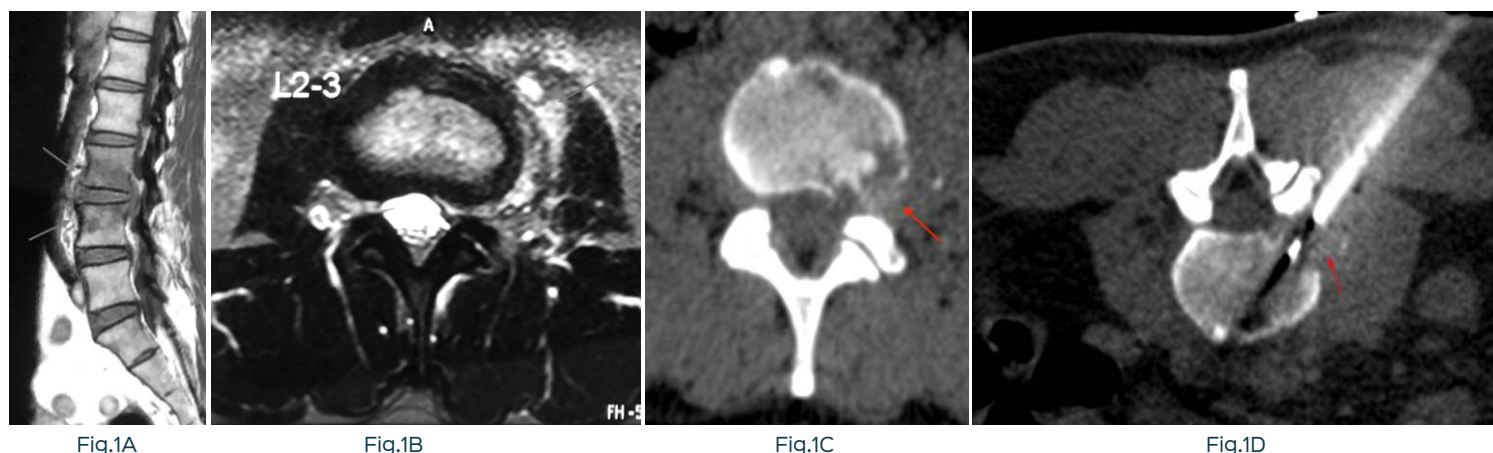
(A-D): Sagittal T1W (A) MRI shows a discovertebral lesion with marrow edema of the L2 and L3 vertebral bodies (arrows), with abnormal left perivertebral soft tissue on the axial STIR (B) image (arrow). The CT scan (C) shows an osteolytic lesion with abnormal soft tissue (arrow), which was then biopsied (D).
